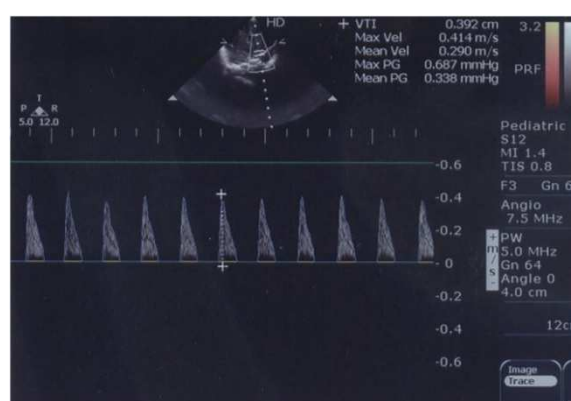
Ultrasound coronal scan for middle cerebral artery show abnormal wave flow pattern with no diastolic flow.
